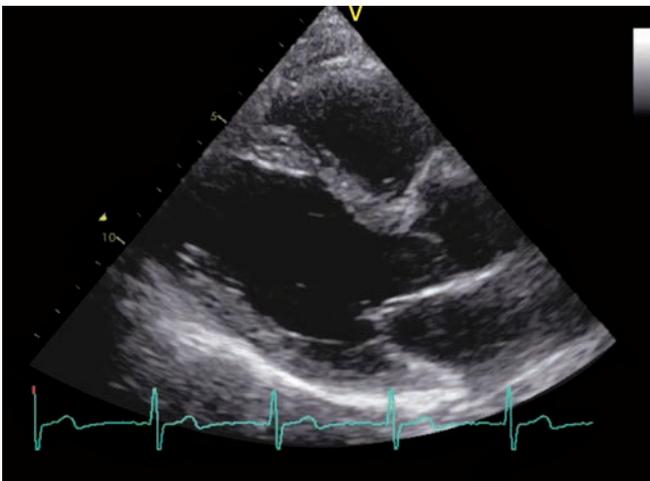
2D TTE. Parasternal long axis view of an asymptomatic 60-year-old male showing normal left ventricular size with mild hypertrophy.
